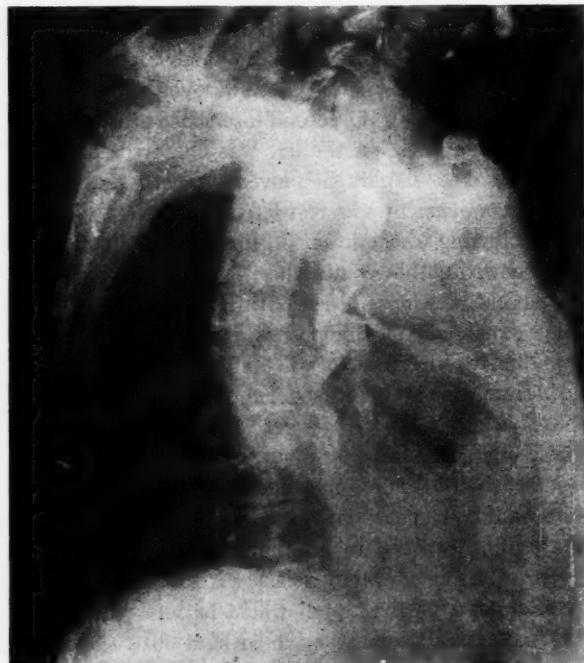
Roentgenogram in oblique position showing barium in the esophagus and bronchi.
